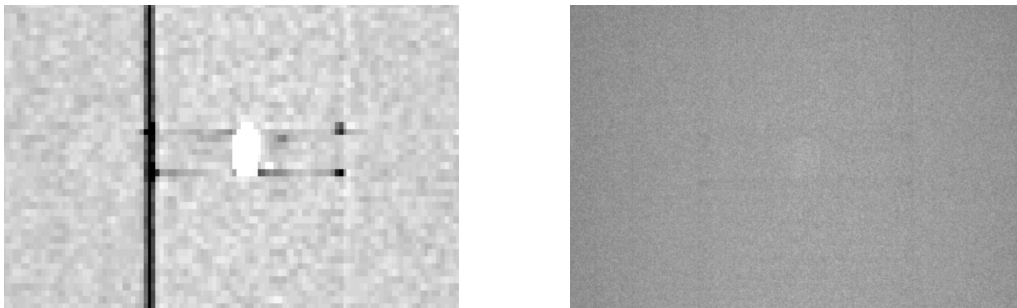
Comparison of CT image (left) and imaging projection (right)
